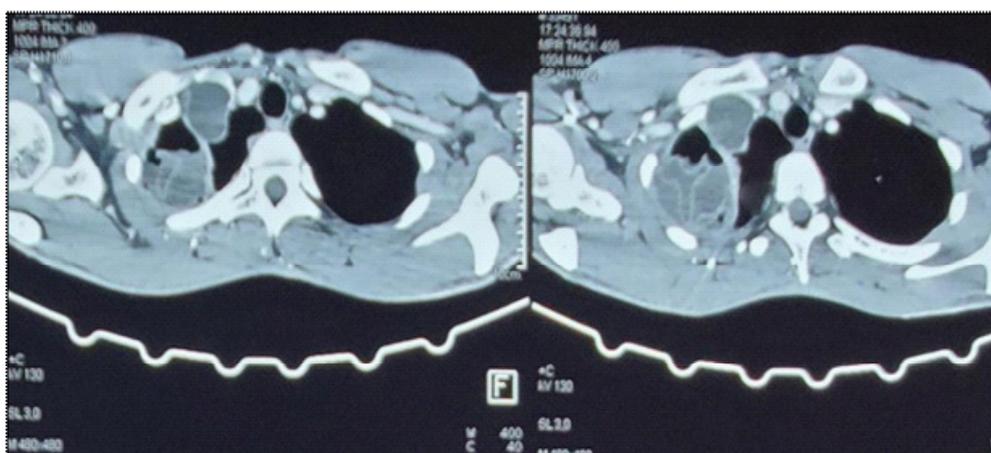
Injected chest CT scan showing right upper lobe pulmonary hydatidcysts
